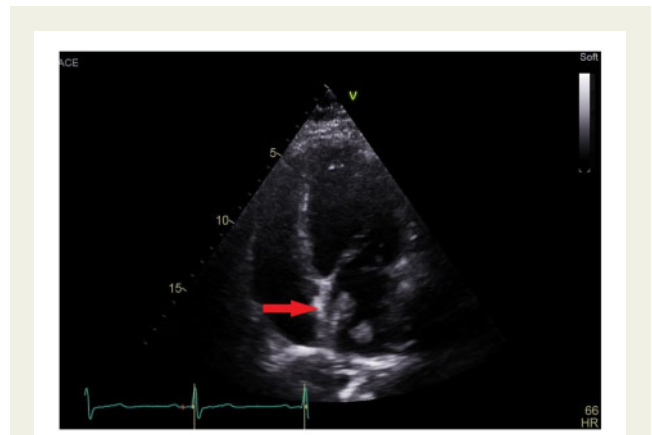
Apical four-chamber view demonstrating significant separation of the left atrial disc from the inter-atrial septum which represents a potential nucleation point for the development of thrombus. Mobile left atrial thrombus attached to the patent foramen ovale-closure device is also demonstrated.
